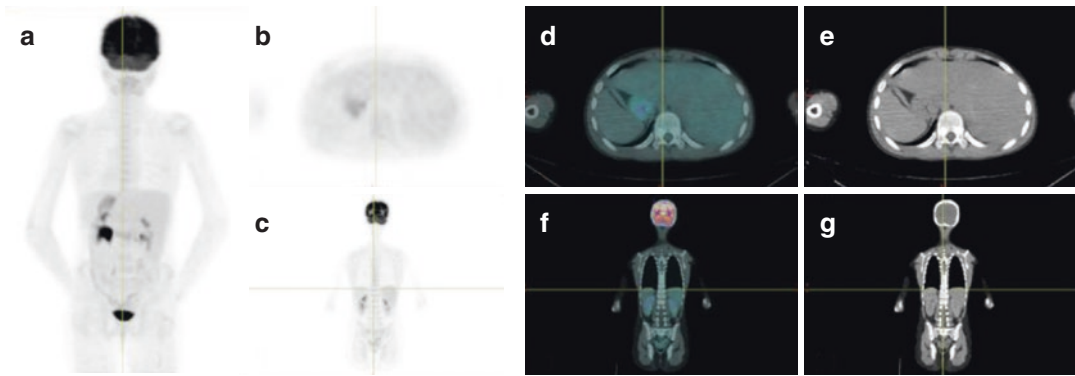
(a–g) FDG-PET/CT initial staging study
